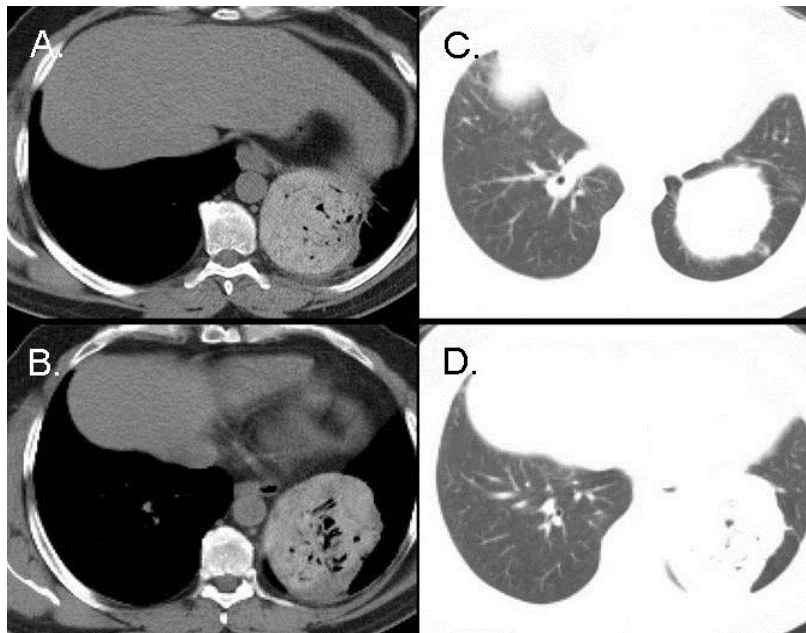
Representative still thoracic soft tissue (Panels A and B) and lung (Panels C and D) CT images.
